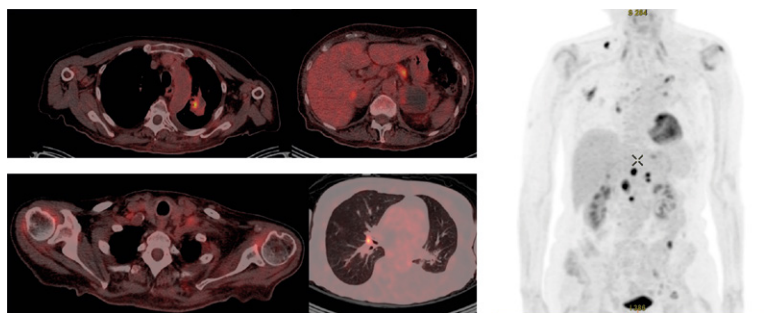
PET CT of non-small cell lung cancer patient from Institute of Oncology Ljubljana, three months after immunotherapy on June 2017.
